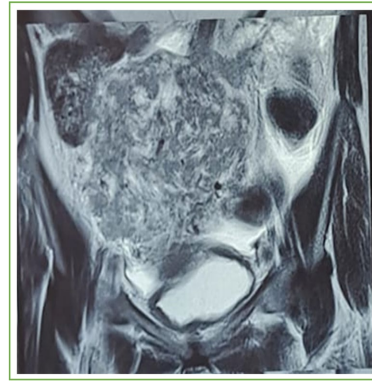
Pelvic MRI—T2-weighted coronal section.
